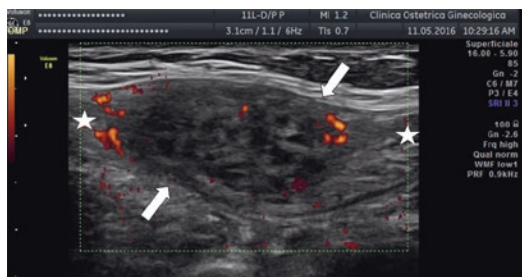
The power Doppler ultrasonographic appearance of a *rectus abdominis endometriosis* (straight arrows) in a 30-year-old woman with one previous cesarean section 4 years before. The muscular layer (star)
